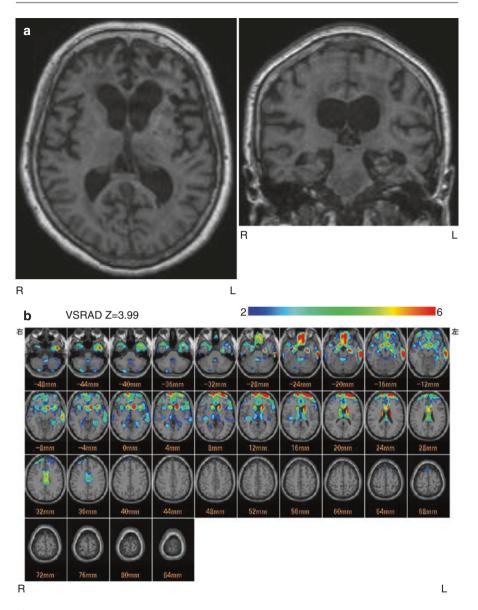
(a) MRI (T1) images of bvFTD. The axial (*left*) and coronal (*right*) images demonstrate frontotemporal atrophy. (b) The result of VSRAD analysis (normal healthy volunteers vs. bvFTD individual). The colored areas show the regions with atrophy in the bvFTD individual compared with the normal healthy volunteers. (c) ^{99m}Tc-ECD SPECT images of bvFTD individual. The axial views demonstrate frontal and anterior temporal hypoperfusion. (d) The result of eZIS analysis (normal healthy volunteers vs. bvFTD individual). The colored areas show the regions with the normal healthy volunteers vs. bvFTD individual). The colored areas show the regions with hypoperfusion in the bvFTD individual compared with the normal healthy volunteers
